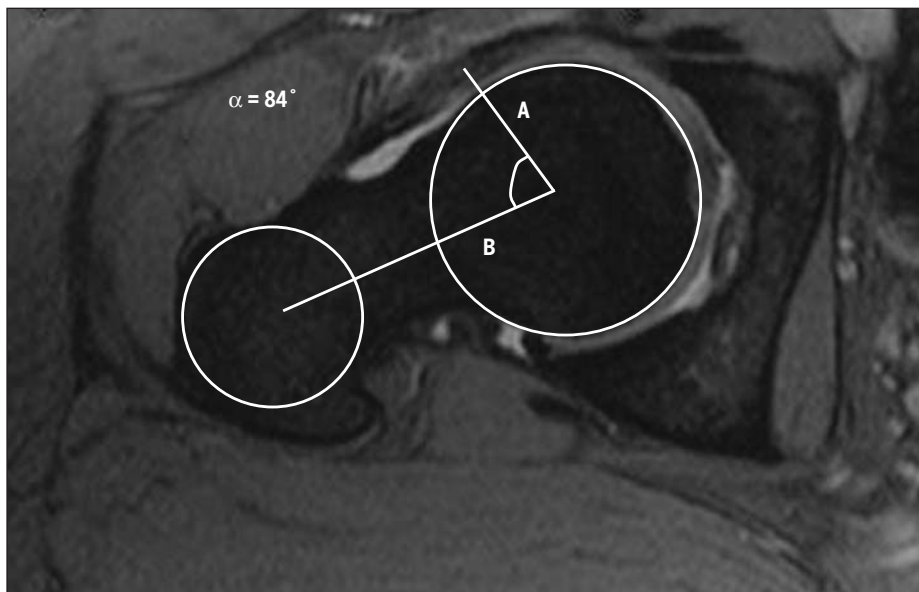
T2 axial oblique magnetic resonance image of the hip joint using gadolinium contrast. The image demonstrates an alpha angle of 84° , indicating the presence of cam impingement. The alpha angle is defined by the intersection of 2 lines. The first line extends from the center of the femoral head to the point on the anterior aspect of the femoral head-neck junction where the radius of the femoral head (A) exceeds that of a best-fit sphere drawn around the femoral head. The second line extends from the center of the femoral head through the femoral neck axis (B).
